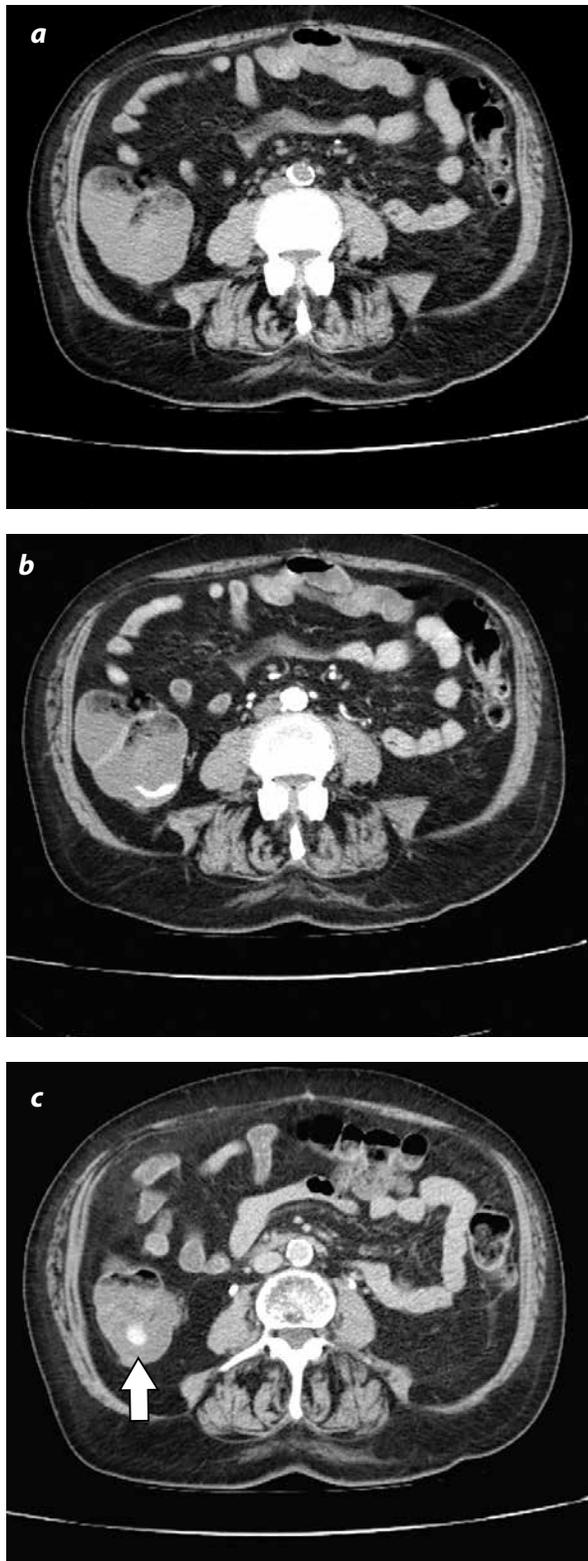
Lower digestive haemorrhage in 85 years old patient, with proctorrhagia. a) Abdominal CT without intravenous contrast dye. b) CT with intravenous contrast dye in the arterial phase that shows the active bleeding that affects the right colon. Note that in figure a) the absence of contrast dye does not allow its diagnosis. c) CT in the venous phase in which the change in the aspect of the foci of bleeding is observed (arrow).
